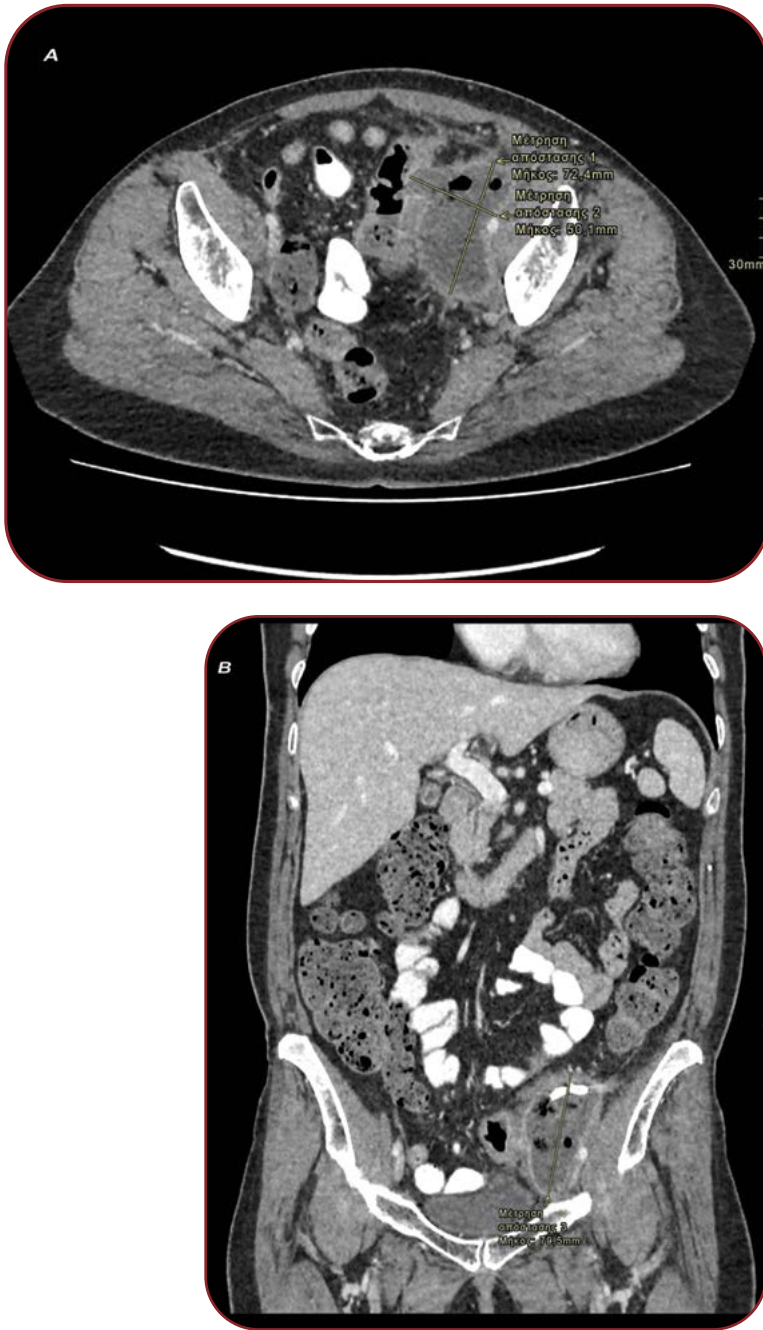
(A) Axial and (B) coronal contrast-enhanced computed tomography (CT) images of the abdomen and pelvis, seven days after percutaneous drainage of the collection, showing a residual abscess cavity (7.2 × 5.0 × 7.9 cm) in the left iliac fossa with a fistulous communication between the sigmoid colon and the collection, consistent with sigmoid rupture into the infected cavity
